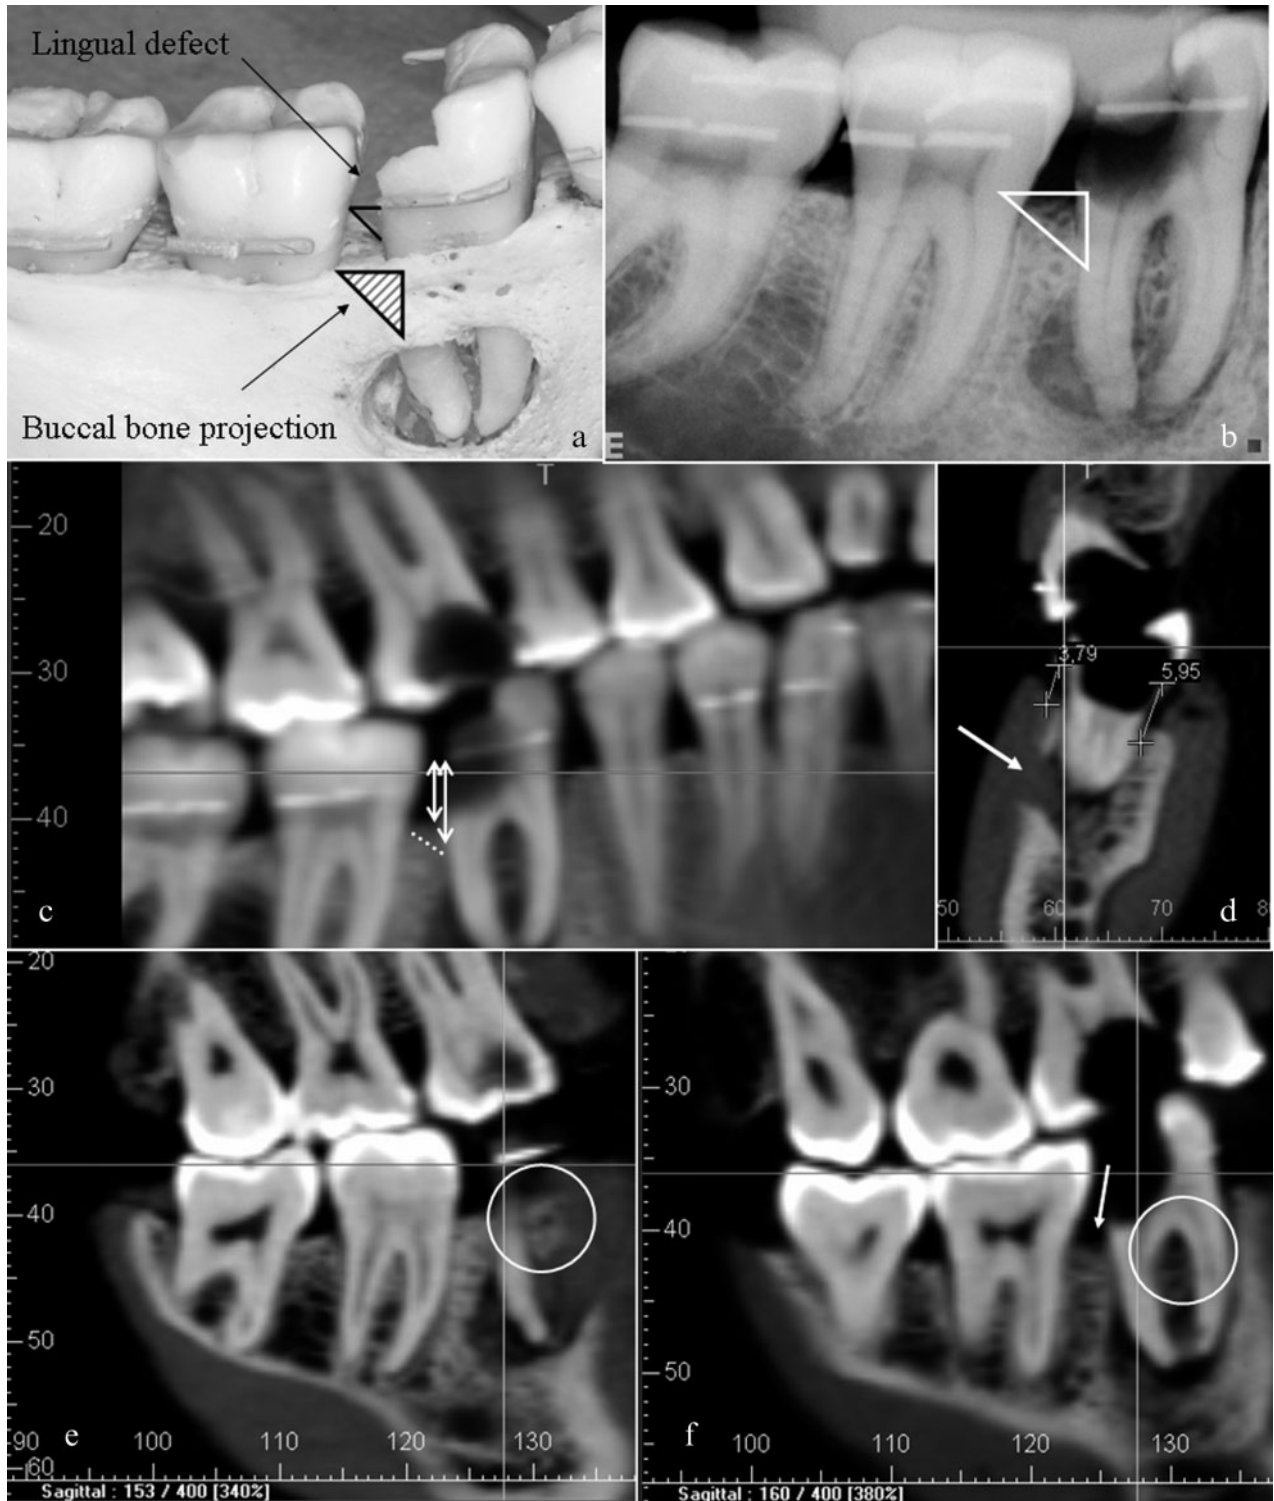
Periodontal assessment of the mandibular right first molar. Before covering the dry skull with soft tissue substitute, the gold standard of bone levels and defect topography were taken. On the distolingual side of the selected tooth, (a) a large defect, which could be difficult to assess on (b) two-dimensional intraoral radiographs due to overlap of the buccal bone plate, was clearly seen. (c) Using a panoramic reconstruction of cone beam CT (CBCT) slices for bone level assessment, measurements are not significantly different from those on charge-coupled device images. However, the same projection overlap is seen (dotted line shows the possible defect border). (d) When measuring on individual coronal or sagittal slices of 0.4 mm, buccal and lingual levels or defects can clearly be separated (also note the buccal plate perforation shown by the arrow). Using these separate CBCT slices, ((e) sagittal slice 153 and (f) sagittal slice 160) a clear three-dimensional effect is obtained, allowing accurate crater topography assessment and furcation involvement evaluation ((e,f) both circles show the bone levels around the bifurcation; the arrow in (f) shows the crater delineation)
